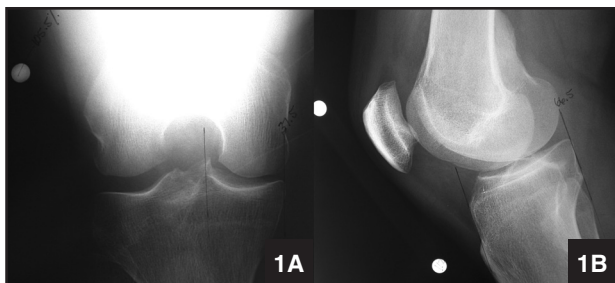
AP (A) and lateral (B) sizing radiographs demonstrating markings used to calculate graft dimensions for meniscal transplantation.
